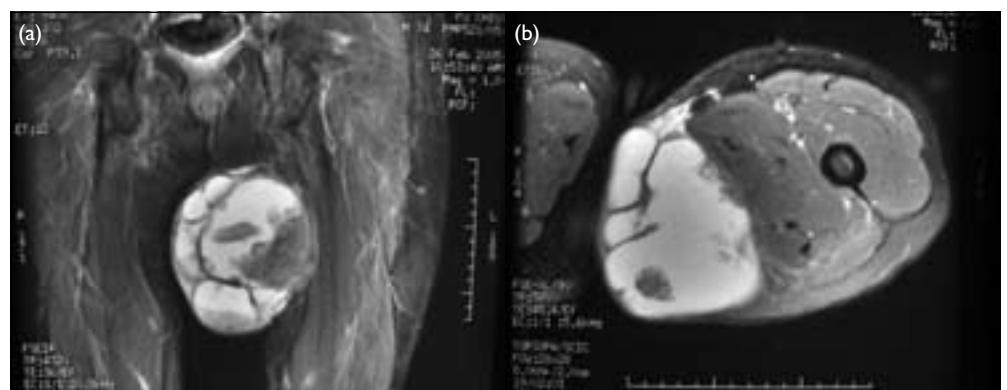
Magnetic resonance image of the left thigh mass (T2 image)
